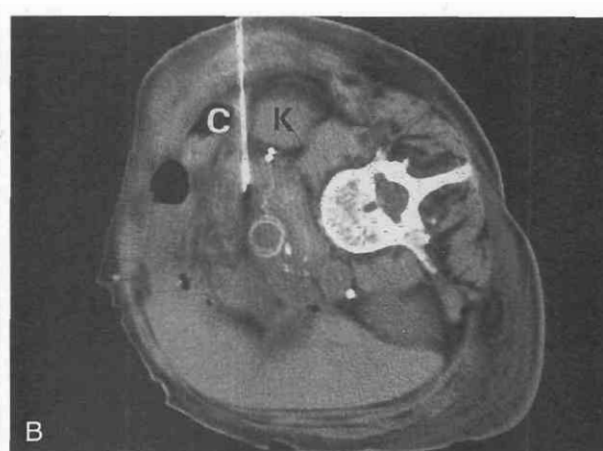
Suspected graft infection. A, CT scan of a patient in the decubitus position before needle procedure. There is a large amount of fluid and old blood in front of and behind the prosthetic graft (A). B, To separate cultures and prevent cross-contamination, separate aspirations from the anterior and posterior areas were taken. The needle is carefully guided between the colon (C) and kidney (K) to ensure sterility. The "double" appearance of the needle is the result of motion. C, A more posterior approach was taken for the aspiration of the posterior fluid collection. A trajectory was planned through the psoas muscle to prevent any possible contamination.
